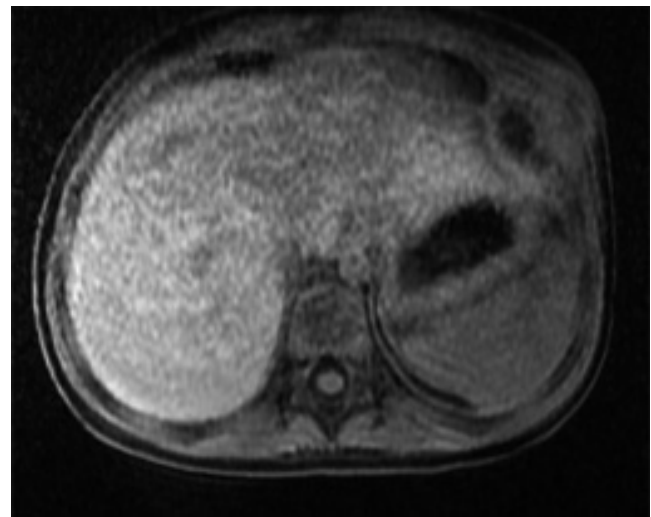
On T1W MRI with axial contrast, a mass lesion originating from the 6th rib, 24x32x30 mm in size, hypointense in the center, cystic-necrotic structure, peripheral hyperintense solid construction, peripheral enhancement, extending into the soft tissue.
